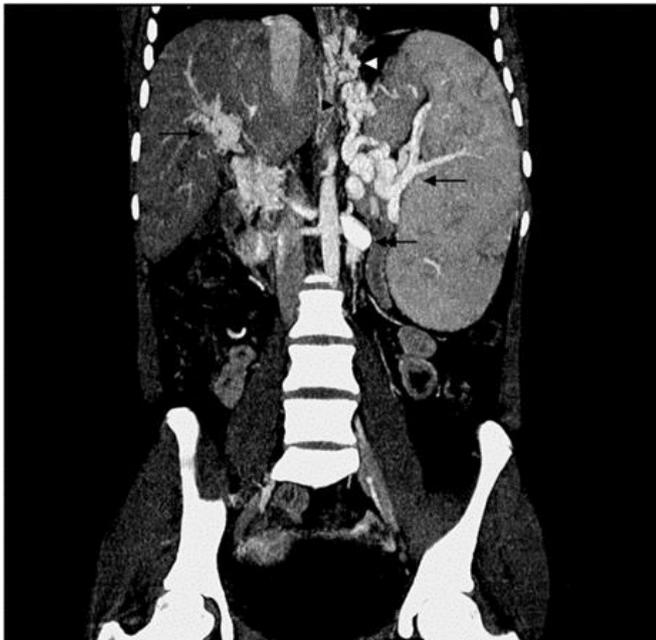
Coronal maximum intensity projection (MIP) CT portal venogram in a patient with extrahepatic portal hypertension shows replacement of the main portal vein by cavernoma formation(→), splenic hilar collaterals(←), tortuous collaterals along gastrohepatic ligament(>) with prominent lower esophageal varices(<). Also noted is a dilated left renal vein(<←) and splenomegaly.
